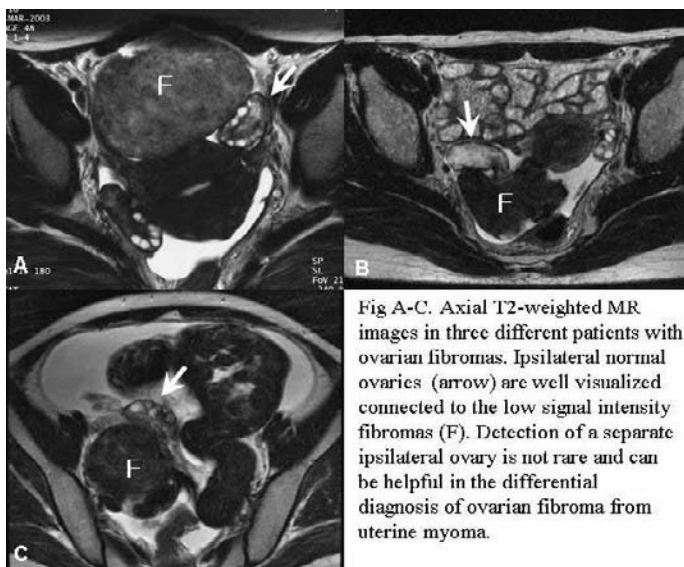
Fig A-C. Axial T2-weighted MR images in three different patients with ovarian fibromas. Ipsilateral normal ovaries (arrow) are well visualized connected to the low signal intensity fibromas (F). Detection of a separate ipsilateral ovary is not rare and can be helpful in the differential diagnosis of ovarian fibroma from uterine myoma.
